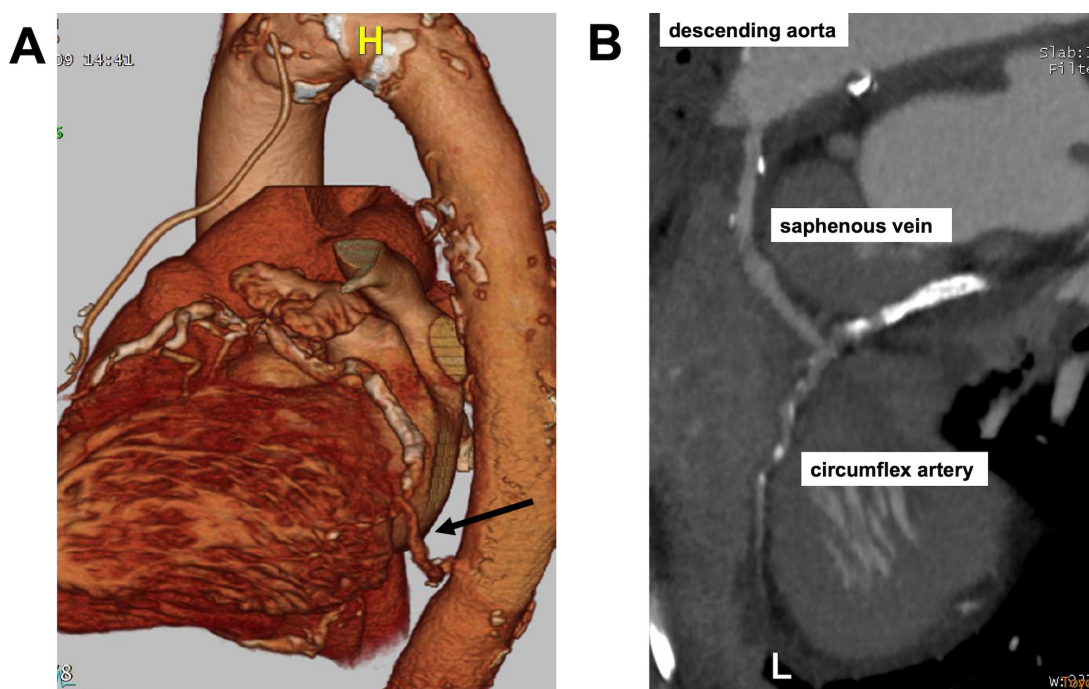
(A) An enhanced CT scan performed 6 months after surgery revealing a patent graft. Black arrow: saphenous vein graft. (B) Curved-multiplanar reconstruction image demonstrates the patent graft at the descending aorta.
